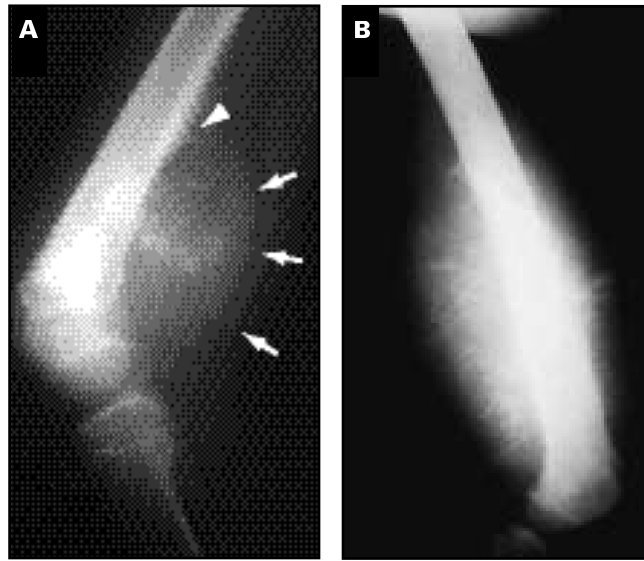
A, Lateral radiograph of the distal femur demonstrates typical radiographic features of osteosarcoma. Radiodense, cloudy bone lies within an ill-defined radiolucency of the femoral metadiaphysis. The arrows delimit a very large soft tissue mass containing bone matrix. B, Lateral radiograph in a different case demonstrating a very large extraosseous, radiodense mass that contains extensively interrupted periosteal “streamers,” forming a “sunburst” periosteal reaction[30].
